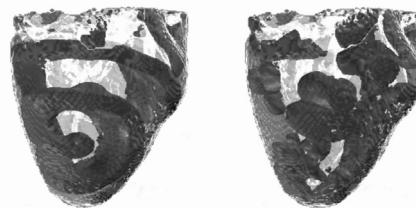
Re-entry and VF in the DT-MRI virtual ventricles. Snapshots of dark-grey voltage isosurfaces are shown within the pale-grey ventricles at 2 s. The slow inward Ca^{2+} current is either normal (right) or decreased by 50% (left), whereas the tissue anisotropy is the same in both cases.
